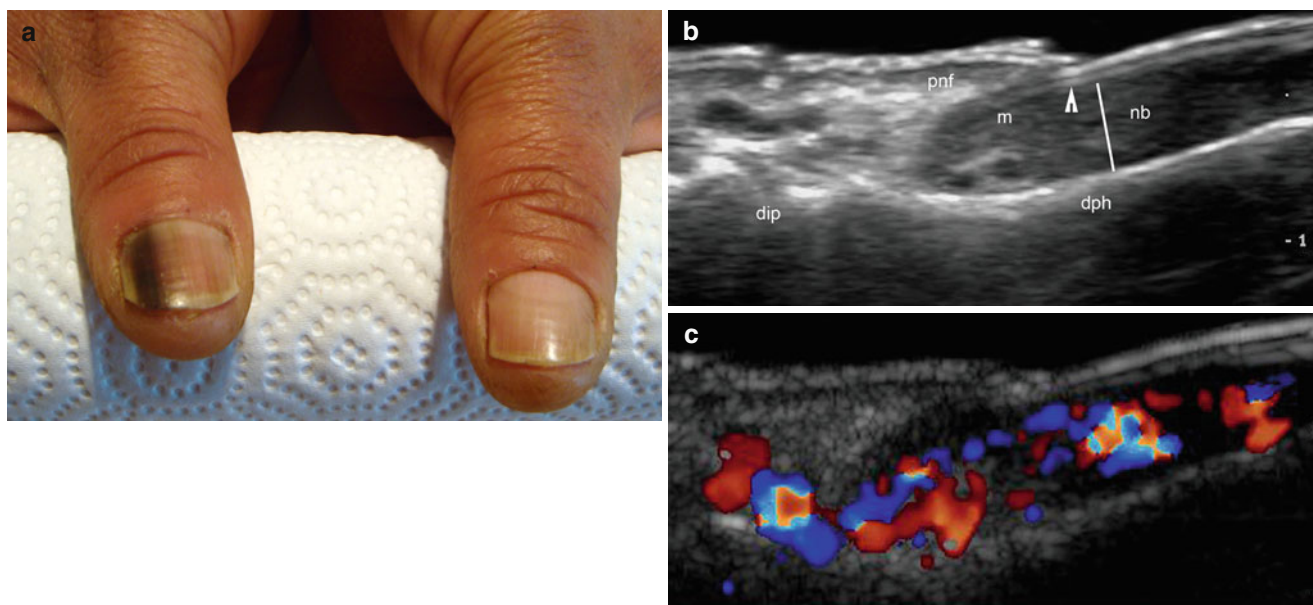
(a–c) Melanoma in situ. (a) Clinical image shows a longitudinal pigmented band in the ulnar aspect of the nail of the right thumb. (b) Grey scale ultrasound image (longitudinal view) shows increased thickness of the nail bed and a mild loss of definition of the ventral plate (arrowhead). No solid mass is detectable. (c) Color Doppler ultrasound
